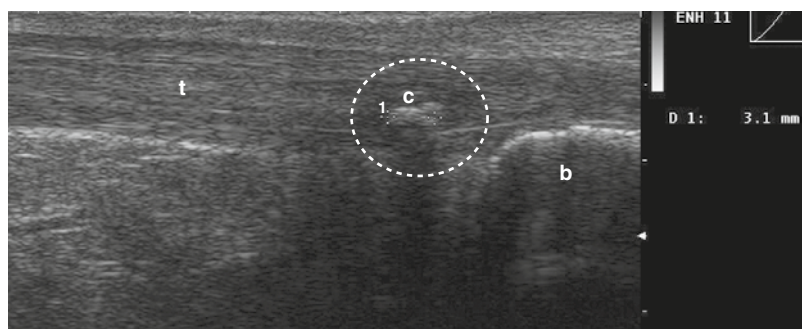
Ultrasound shows calcification (c, dotted circle) of the Achilles tendon (t) with an acoustic shadow. b, calcaneal bone.
